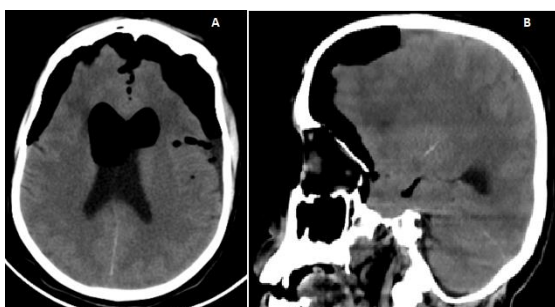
CT Brain performed 24 hours after admission showing reduction in the volume of pneumocephalus
